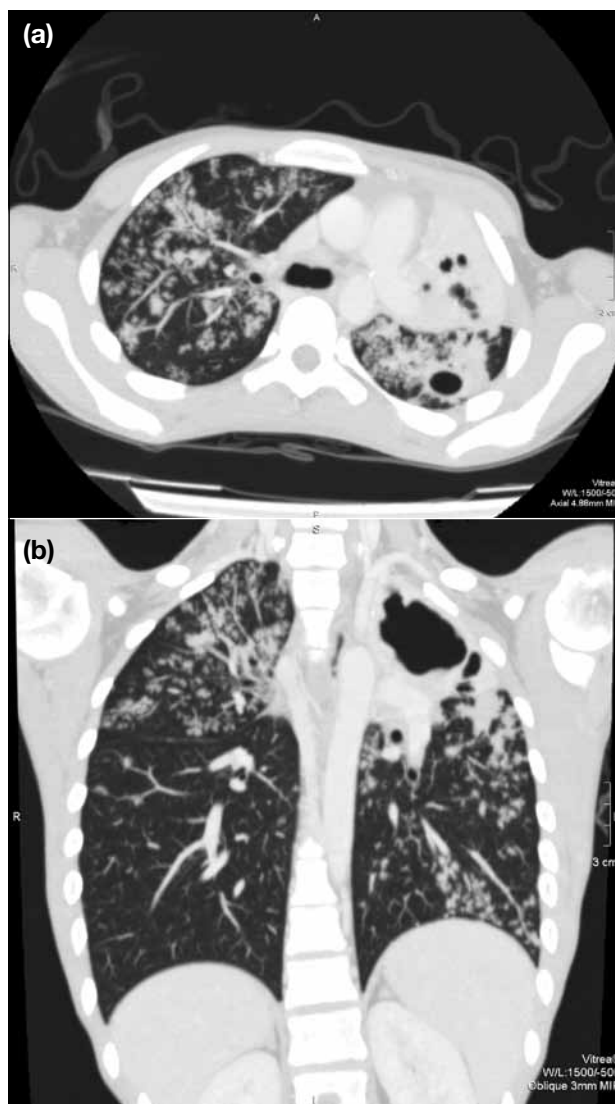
A male adult with confirmed mycobacterial tuberculosis infection: (a) Axial and (b) coronal post-contrast computed tomographic scans of the thorax in lung window and maximal intensity projection showing tree-in-bud opacities in both lungs, associated with a cavitating lesion and consolidation in the left upper lobe.
